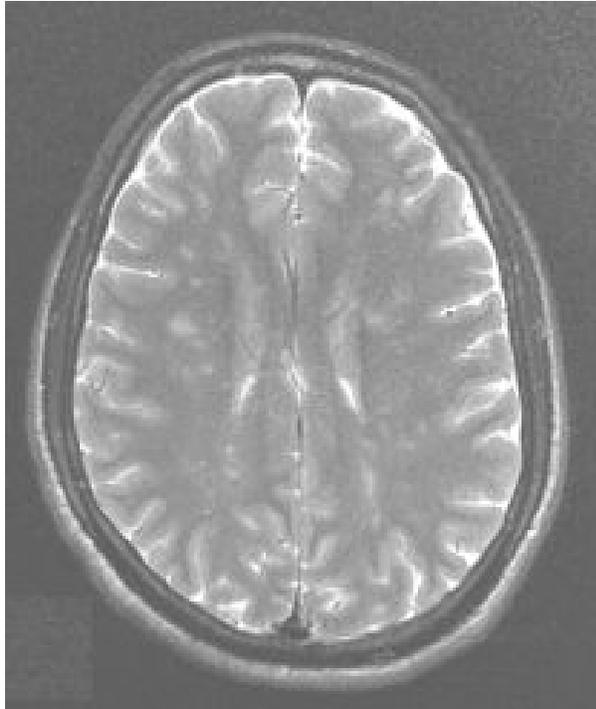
T2-weighted Magnetic resonance imaging showed small hyperintense lesions located at subcortical and deep white matter of both cerebral hemispheres.
